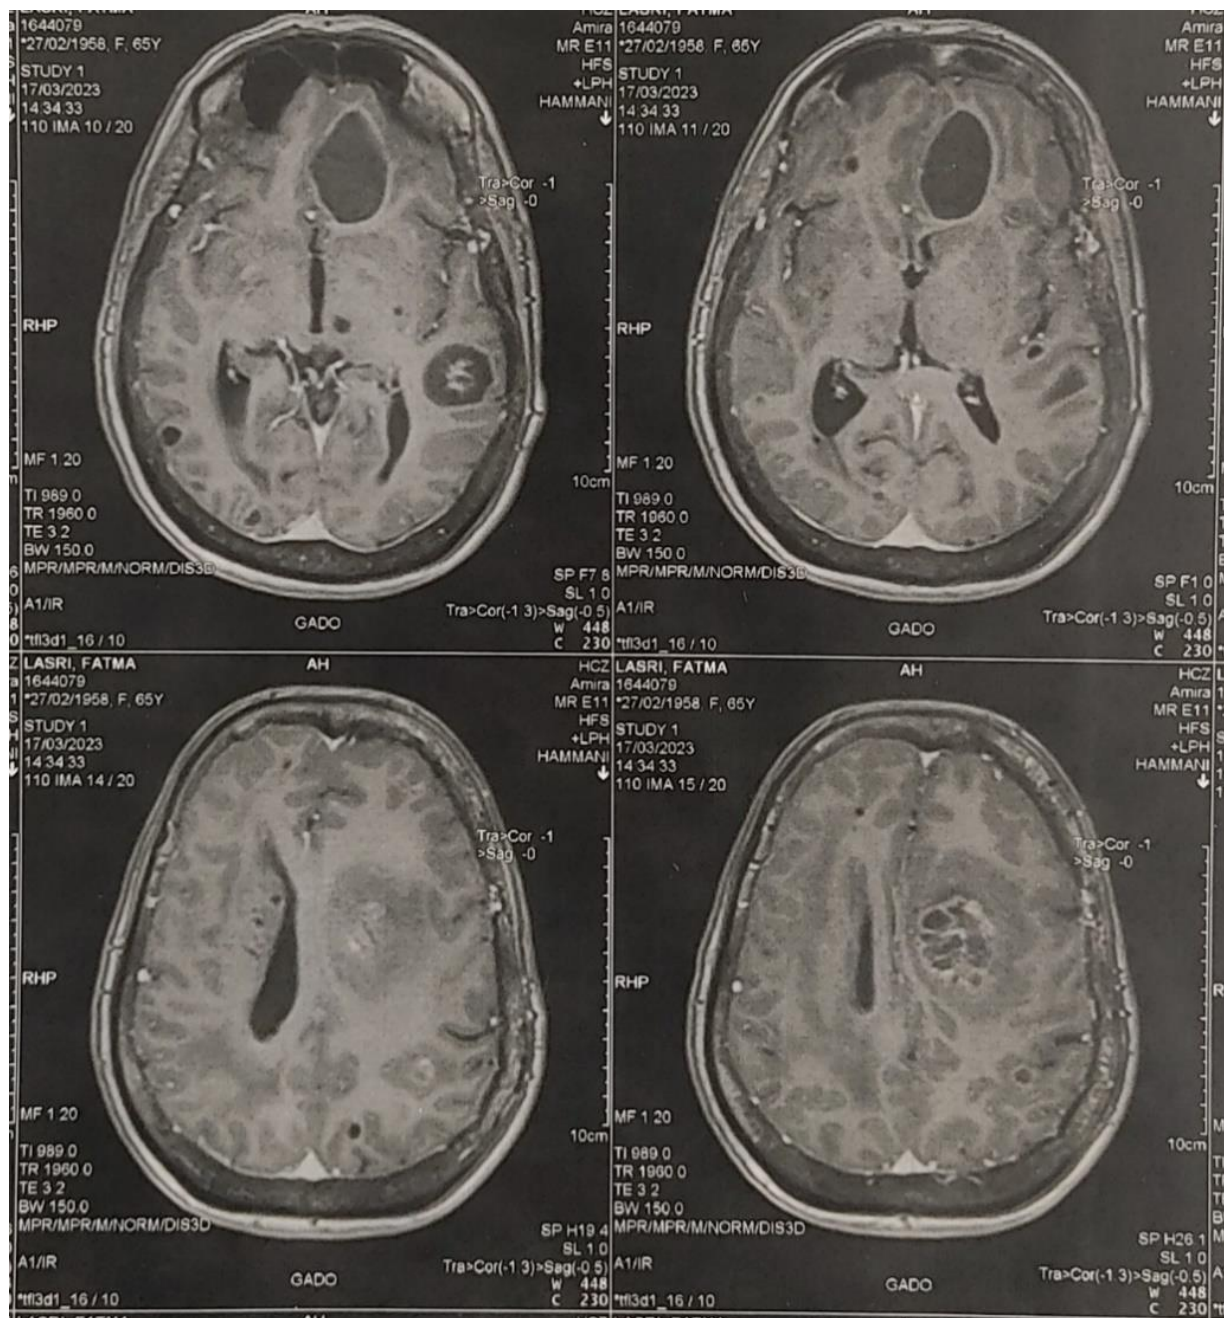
Brain MRI showing multiple cystic intraparenchymal metastases from lung adenocarcinoma
